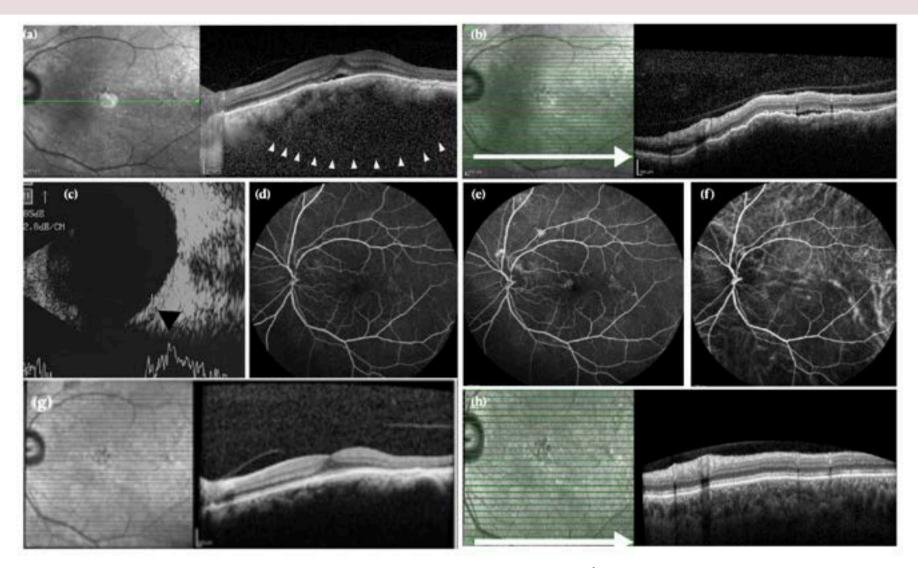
Left eye of a 65-year-old-male with BCVA 20/30 revealed smooth elevated mass lesion in the inferotemporal macula and inferotemporal vascular arcade – At presentation, EDI-OCT showing subfoveal fluid, choroidal elevation, a grossly thickened choroid and outer choroidal hyporeflective lumina without clear demarcation (interdigitated loculation) (white arrowhead) (a), OCT through the lesion (scan line highlighted as white arrow) showing subretinal fluid, RPE undulation with choroidal elevation (b), ultrasonography showing localized thickening of RCS complex (black arrowhead) (c), fluorescein angiography showing normal features with few points of RPE leakage in the mid and late phases (d and e), and, Indocyanine-green angiography showing dilated outer choroidal vessels (pachyvessels) (f). EDI-OCT through the line corresponding to A and B, at 8 weeks of follow-up after starting oral Eplerenone 50 mg OD, showing complete resolution of subretinal fluid and RPE undulations, flattening of choroidal elevation, and considerable reduction in the size of hyporeflective lumina in the outer choroid (g and h).
